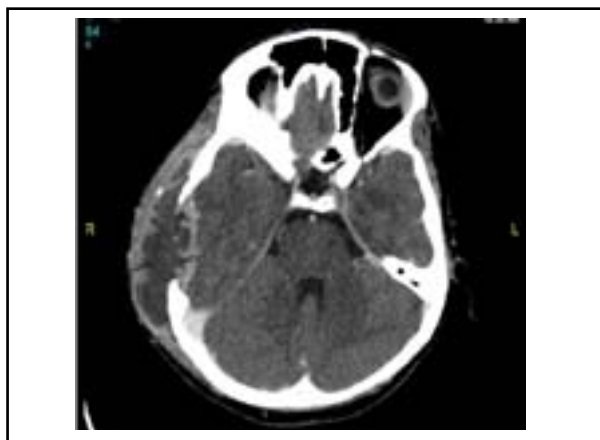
Axial CT scan of the temporal bone at initial presentation demonstrates scalp abscess formation at the right temporoparietal area (white arrow), with destruction of right temporoparietal bone and extension of abscess into adjacent extradural region.
